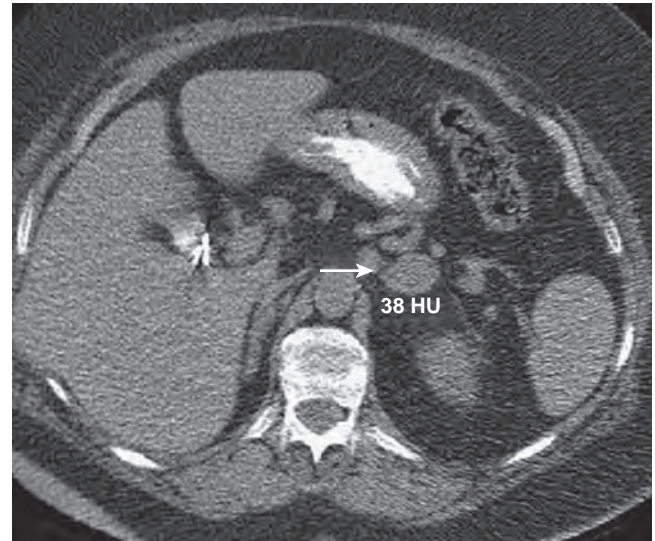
Unenhanced computed tomography scan of a patient with a left adrenal metastasis from right-sided renal cell carcinoma (RCC) that had been resected several years earlier. At presentation, unenhanced imaging revealed a lesion with an attenuation of greater than 10 Hounsfield units (HU), indicating that the adrenal mass was not a lipid-rich adenoma. Recent data reveal that RCC metastases may exhibit washout characteristics similar to lipid-poor adenomas. Metabolic evaluation ruled out pheochromocytoma. Laparoscopic adrenalectomy confirmed metastatic RCC.
